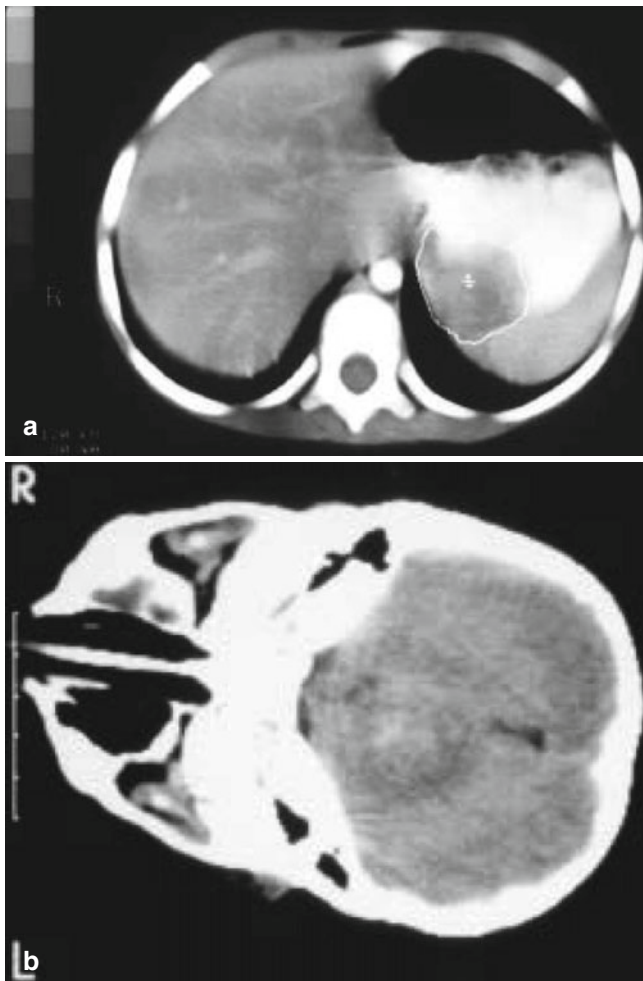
(a) This is a CT scan of a 2-year-old boy who presented with a large abdominal mass. He had a large Wilms' tumor on the left side invading the liver. He subsequently was found to have chromosome breakage syndrome when he became unwell following chemo- and radiotherapy. (b) Two years later after his treatment was completed, he developed signs of raised intracranial pressure. This CT scan of the brain shows a separate brain tumor. He succumbed shortly after treatment was instituted. His brother also died after treatment for a rhabdomyosarcoma of the head and had a second tumor, a ganglioneuroblastoma of the abdomen discovered at post mortem
